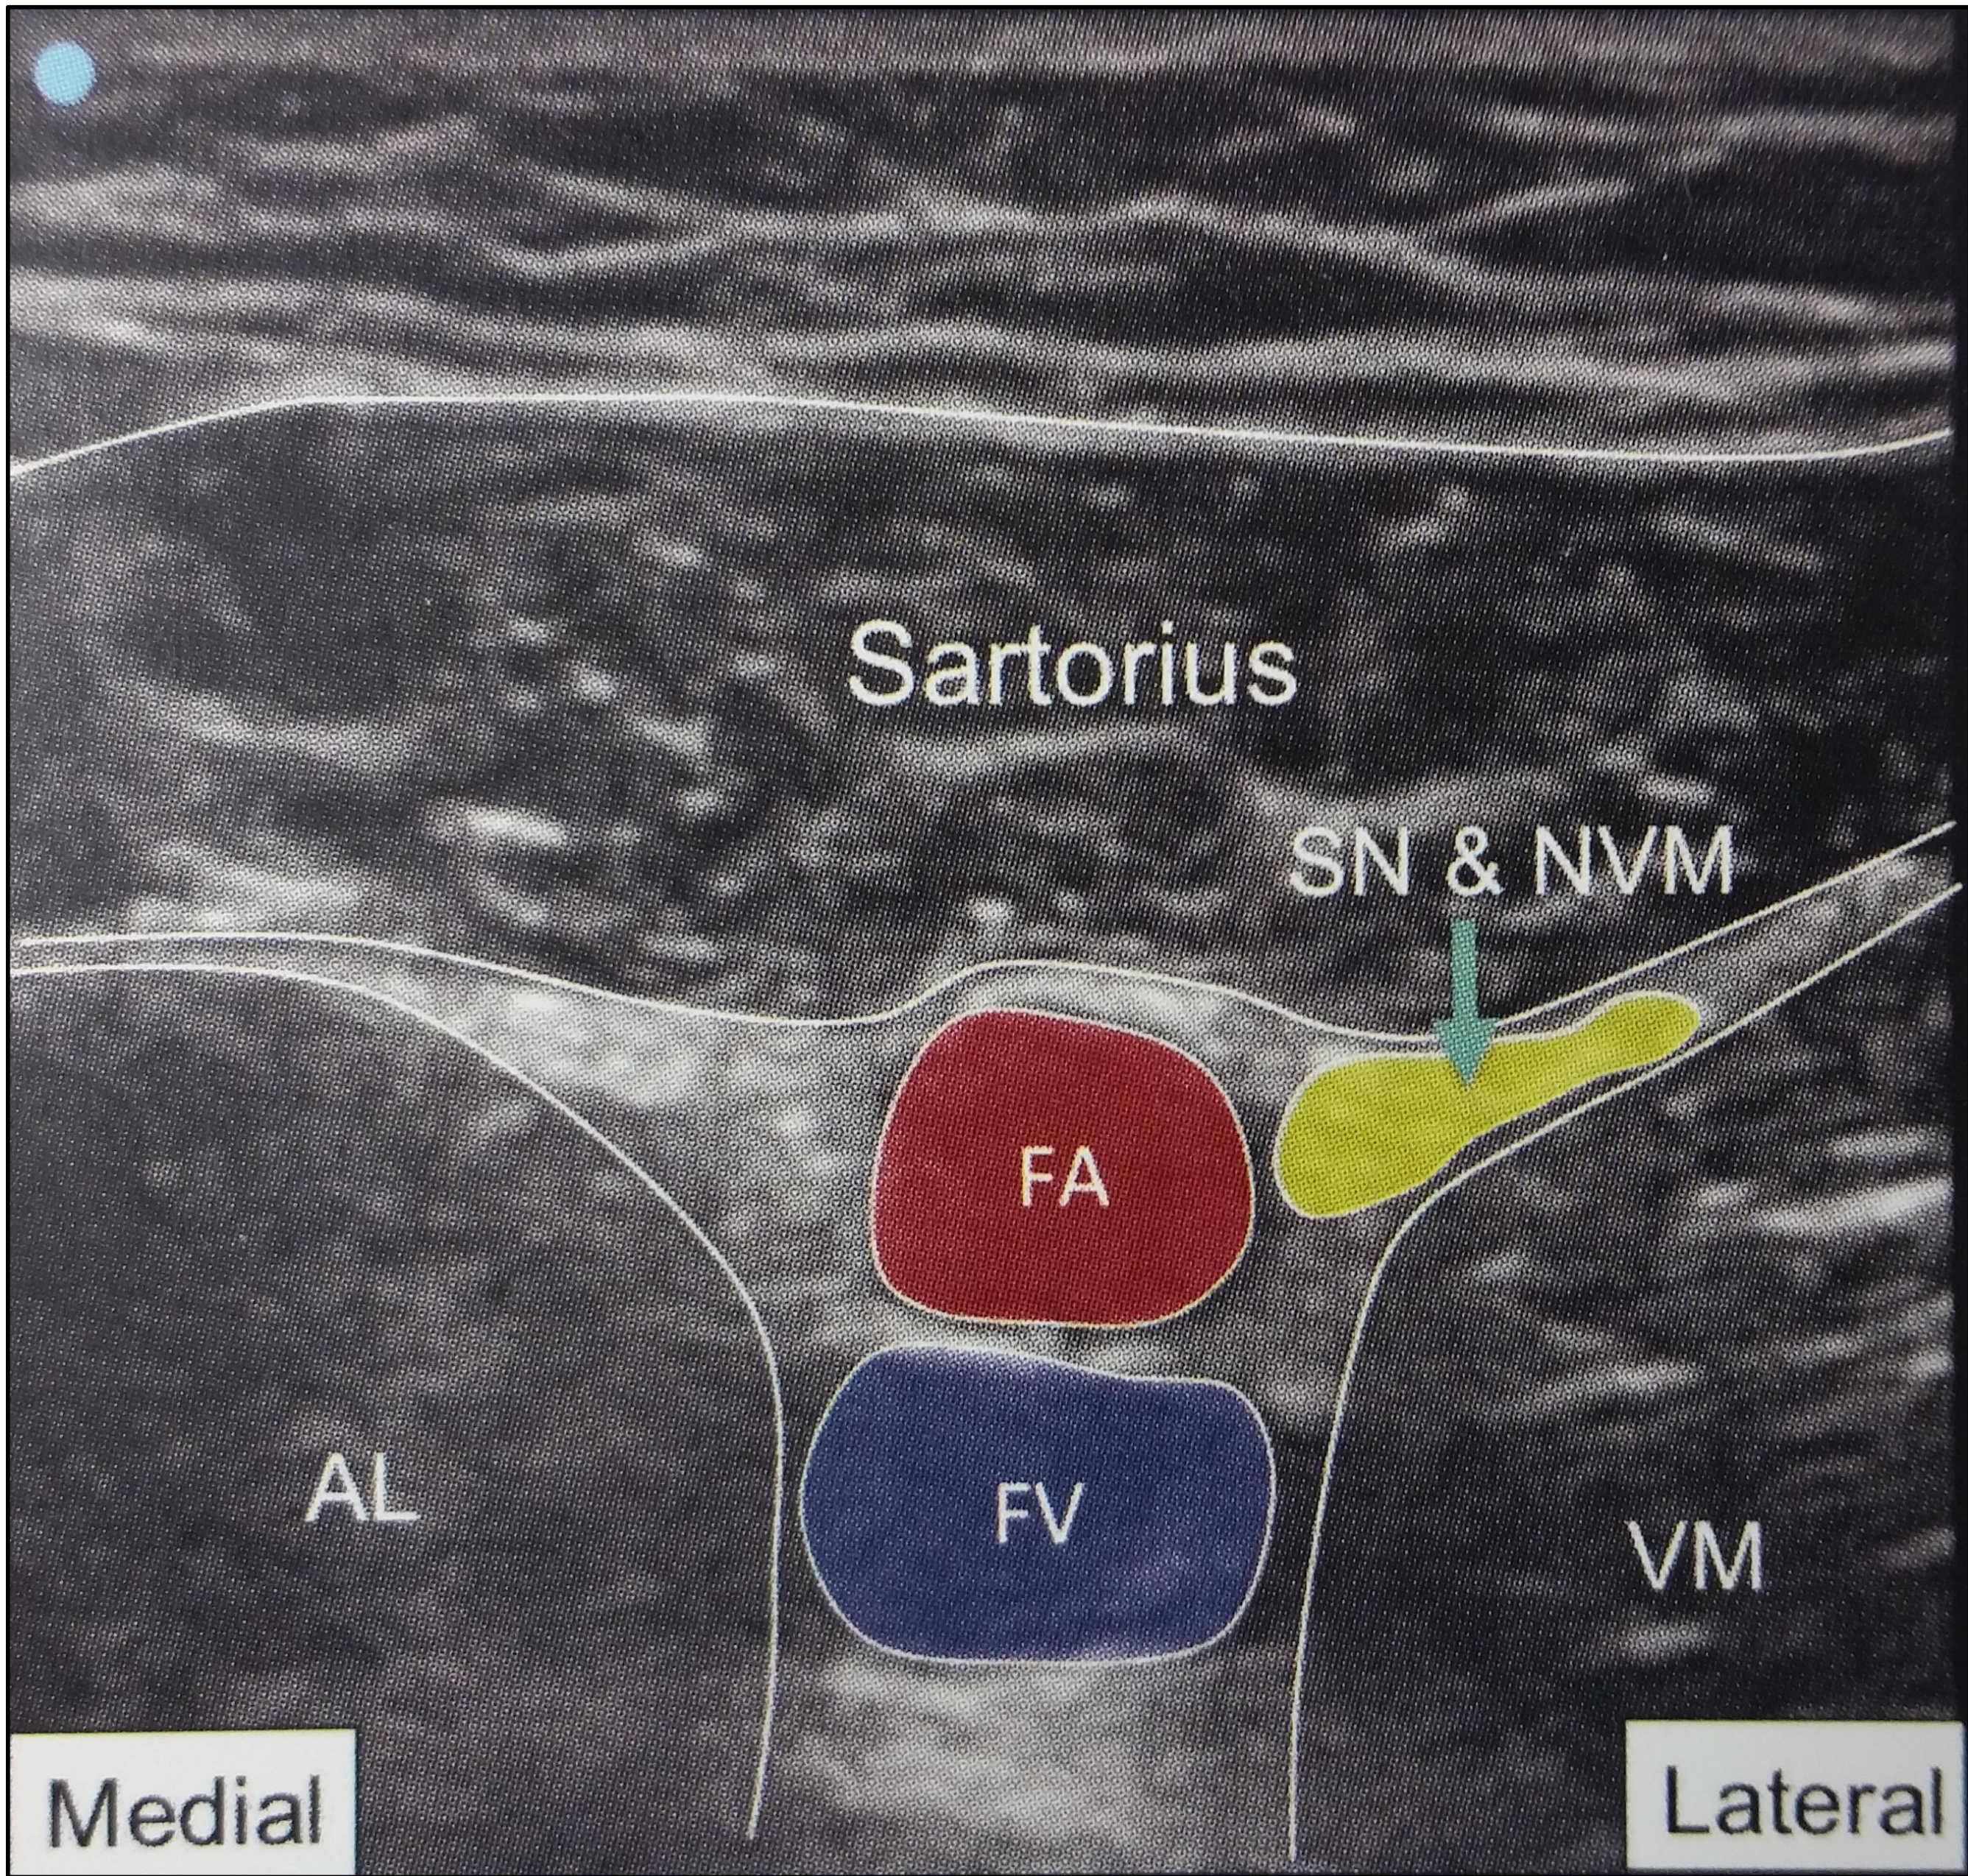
Adductor canal (Reproduced from a pocket guide to ultrasound-guided regional anaesthesia)
